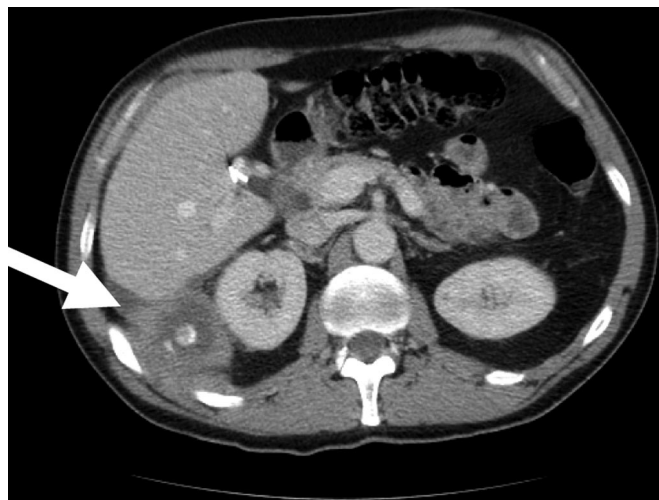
Computed tomography scan showing abscess cavity containing gallstones in case 1. Arrow - Abscess cavity containing gallstones.
